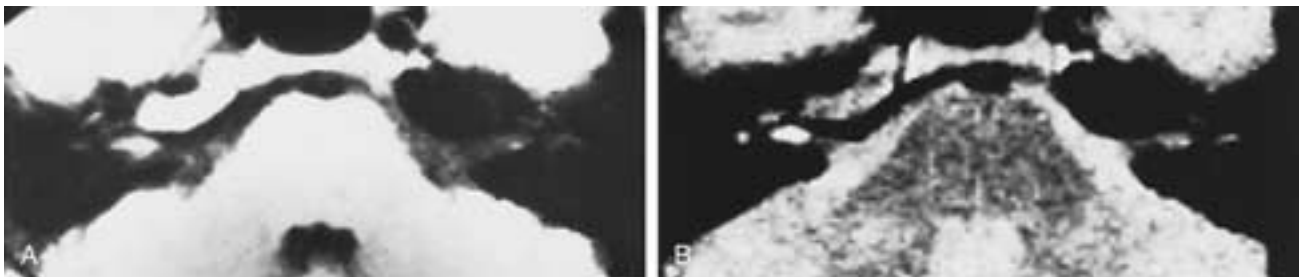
IAC, intratemporal vascular tumor. A and B, T1-weighted and T2-weighted images, respectively. The tumor is more hyperintense on T2-weighted images than is the typical schwannoma. (Courtesy of Dr. Michael Anselmo.) (From Lo WWM, Shelton C, Waluch V, et al. *Intratemporal vascular tumors: detection with CT and MR*. *Radiology* 1989;171:443-448.)
